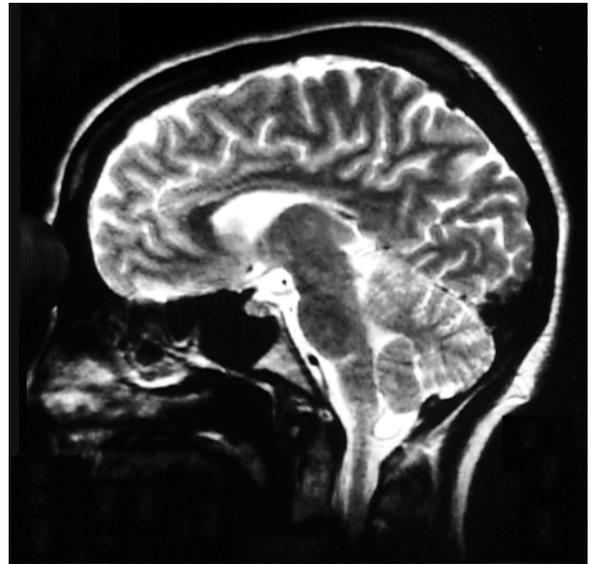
MRI scan of the brain showing the thalamus in relation to the caudate nucleus, midbrain, and corpus callosum. The posterior cerebral artery (main source of blood supply to the thalamus) is indicated
